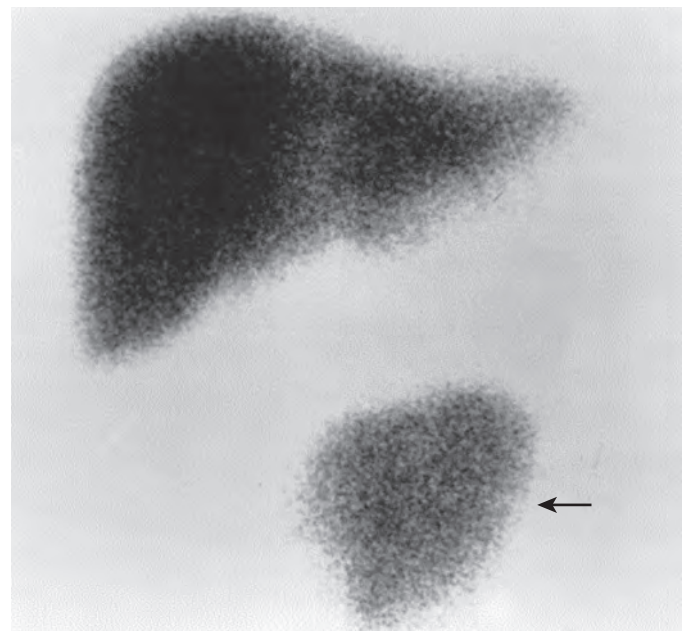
Wandering spleen. Anterior ^{99m}Tc-sulfur colloid scintigram shows absence of radiotracer activity in the left upper abdomen and uptake in an abnormally located spleen in the pelvis (arrow). The liver also shows normal radiotracer uptake (top). (From Paterson A, Frush DP, Donnelly LF, et al: *A pattern-oriented approach to splenic imaging in infants and children*. *RadioGraphics* 19:1465–1485, 1999.)
